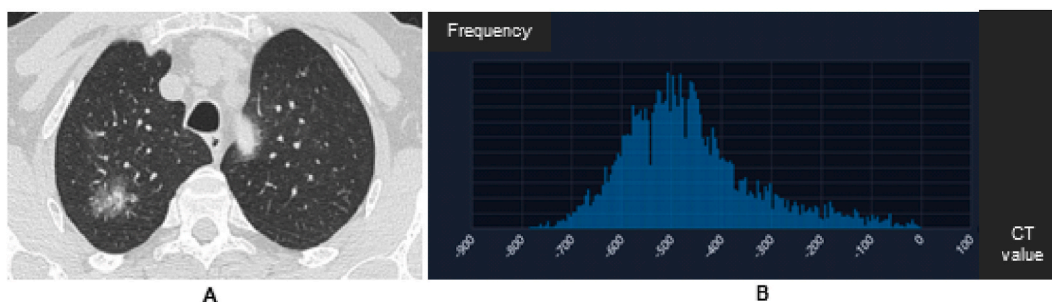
A 67-year-old man with invasive adenocarcinoma (IAC) in the right upper lobe. (a) A transverse thin-section CT (1 mm thickness) scan shows part-solid nodules (PSN) (arrow) with a major diameter of 29 mm, spiculation, lobulation, vacuole sign, air bronchogram and a mean CT value of -463 HU. (b) The three-dimensional (3D) CT values histogram of the PSN was calculated using artificial intelligence (AI) automated image analysis tool.
